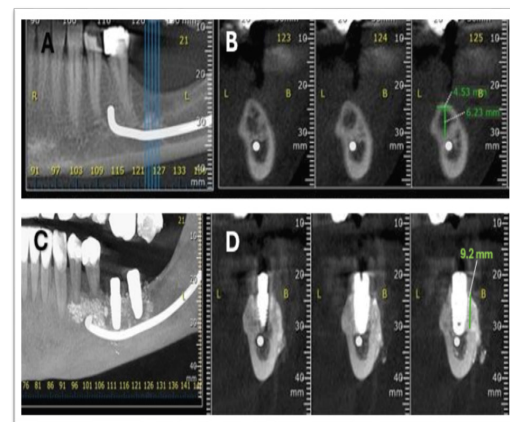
CBCT imaging demonstrating mandibular segmental osteoperiosteal flap with simultaneous implant placement. Upper row shows preoperative assessment: (A) Panoramic reconstruction showing atrophic posterior mandible, (B) Cross-sectional views revealing insufficient vertical bone height. Lower row displays 6-month postoperative outcomes: (C) Panoramic reconstruction (with MIP) showing successful implant integration, (D) Cross-sectional views demonstrating significant vertical bone gain.
